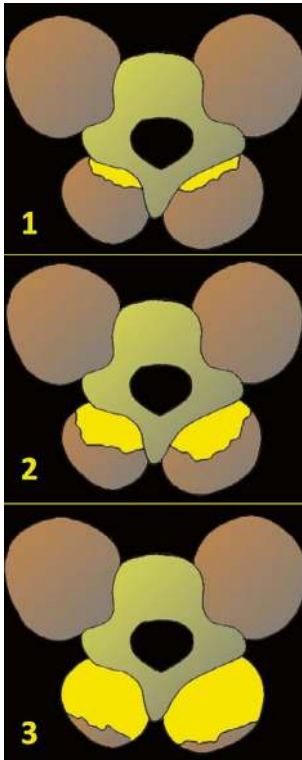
Yellow ligaments hypertrophy on axial T2-weighted image
